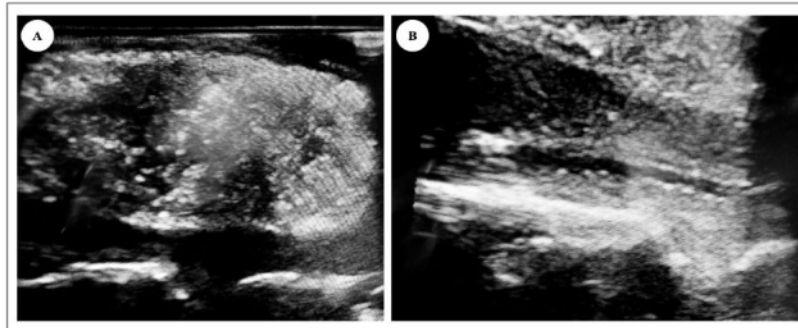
Case 2: Pre-removal (A) and post-removal phase (B) intraoperative ultrasound images.
